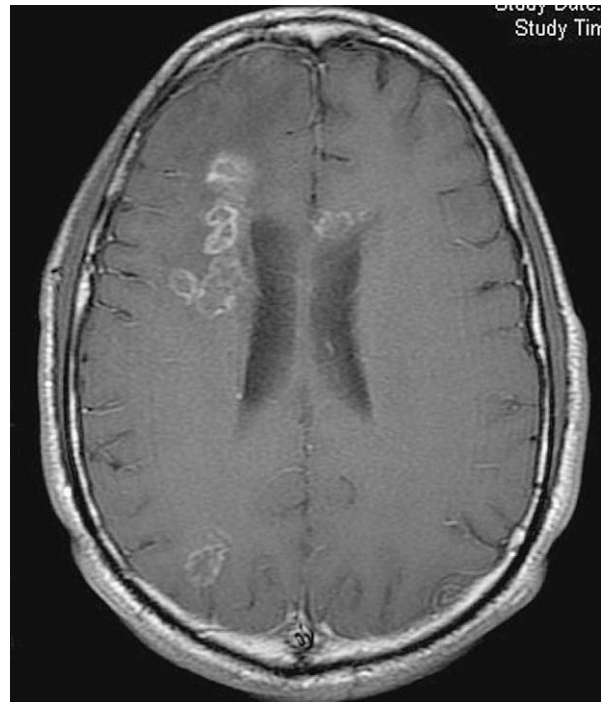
Toxoplasmosis. T1-weighted MRI following gadolinium-DTPA showing multiple ring-enhancing lesions.
